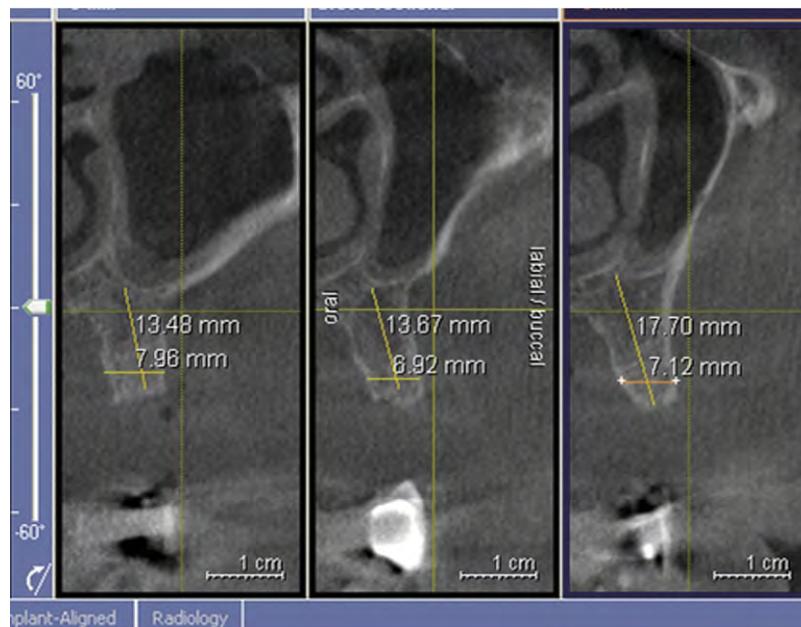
Preoperative implant planning. Assessment of available jaw bone volume and density by using Galileos cone beam CT imaging.
